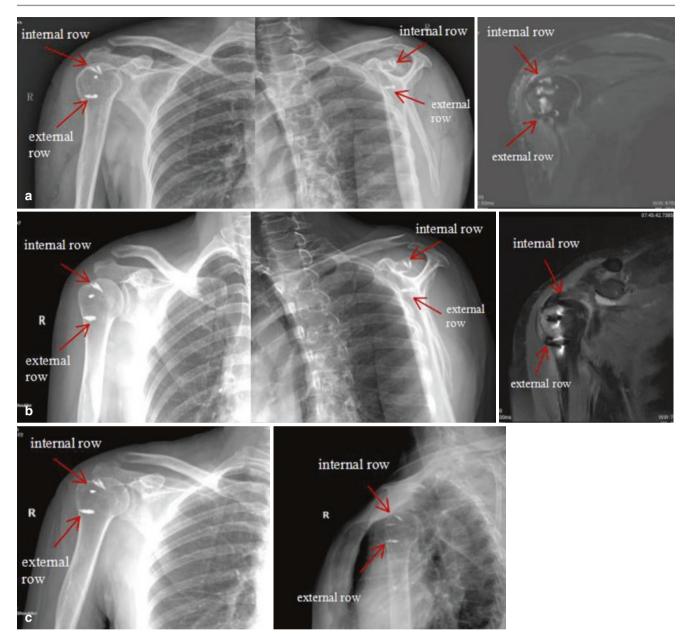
(a) Postoperative right shoulder X-ray and MRI. (b) X-ray and MRI of right shoulder 2 weeks after operation. (c) X-ray of right shoulder 3 months after operation
